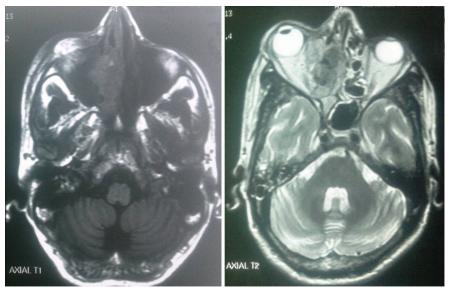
Magnetic resonance imaging showing an expanding mass (3.6  $\times$  1.7  $\times$  2.7 cm) present in the right nasal cavity and compressing the medial walls of the right maxillary sinus and right orbit.
